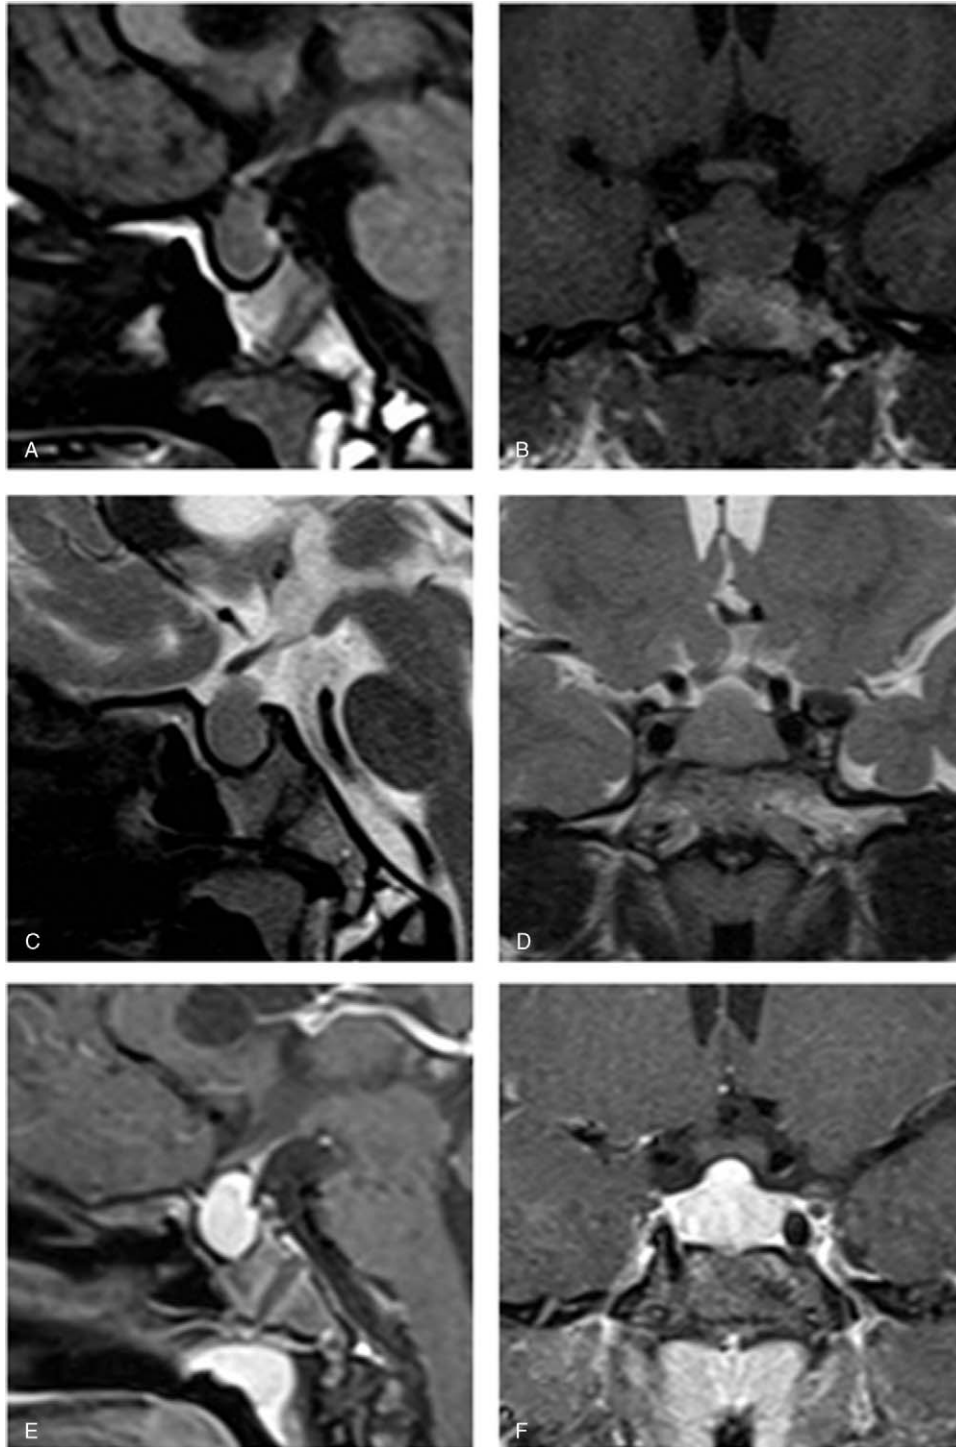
Intracranial MRI of the patient before treatment. A: Sagittal T1WI, uniform signal intensity; B: Coronal T1WI; C: Sagittal T2WI, uniform signal intensity; D: Coronal T2WI; E, Contrast-enhanced, sagittal T1WI, pituitary enlargement with suprasellar extension, significantly uniform enhancement, length 13.4 mm, without oppression of optic chiasm; F: Contrast-enhanced, coronal T1WI, normal signal intensity of cavernous sinus. MRI = magnetic resonance imaging.
